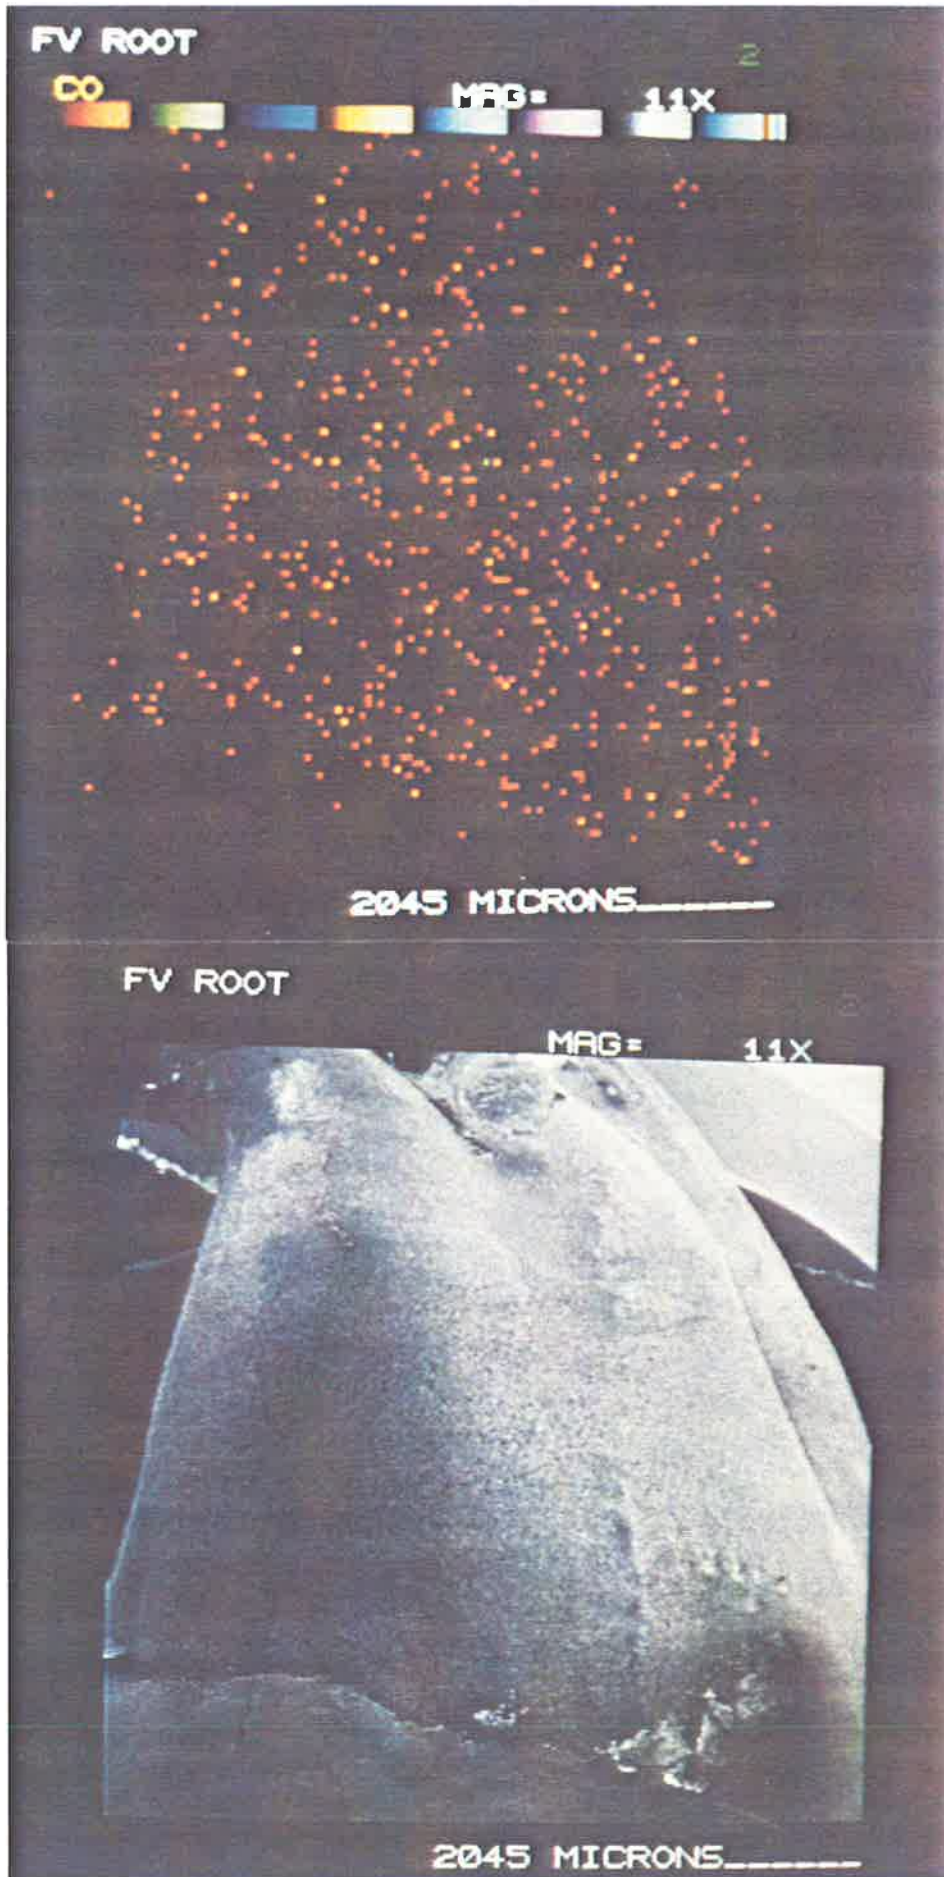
X-Ray Image Representing a Score of Two (SEM Image top).
